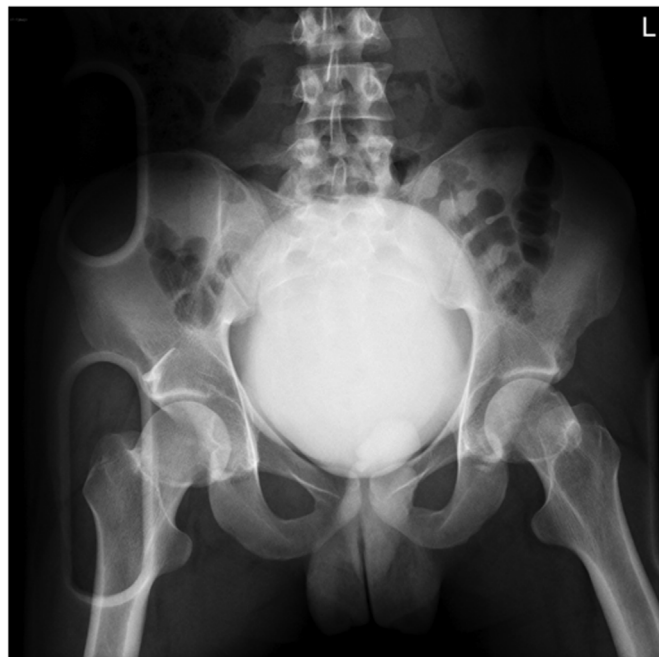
Post-reduction x-ray.
